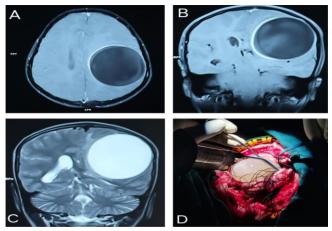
A): Axial T1 weighted MRI Brain showing incomplete ring-enhancing cystic lesion in left front-parietal lobe. B): Coronal T1 weighted MRI Brain showing incomplete ring-enhancing lesion. C): Coronal T2 weighted MRI Brain showing well defined hyperintense cystic lesion. D): Intraoperative image of the hydatid cyst
